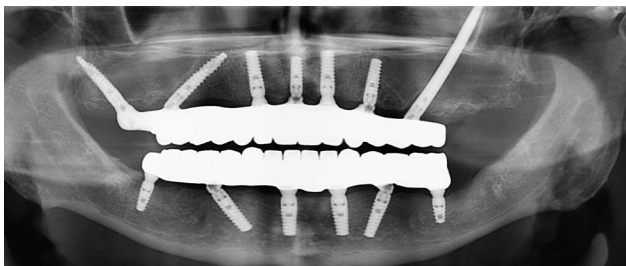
Panoramic radiograph following restoration with final hybrid prosthesis.
